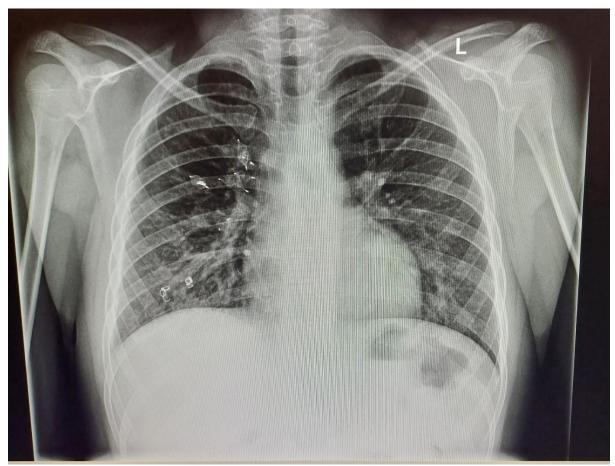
Chest X-ray showing multiple embolization coils on the right side
